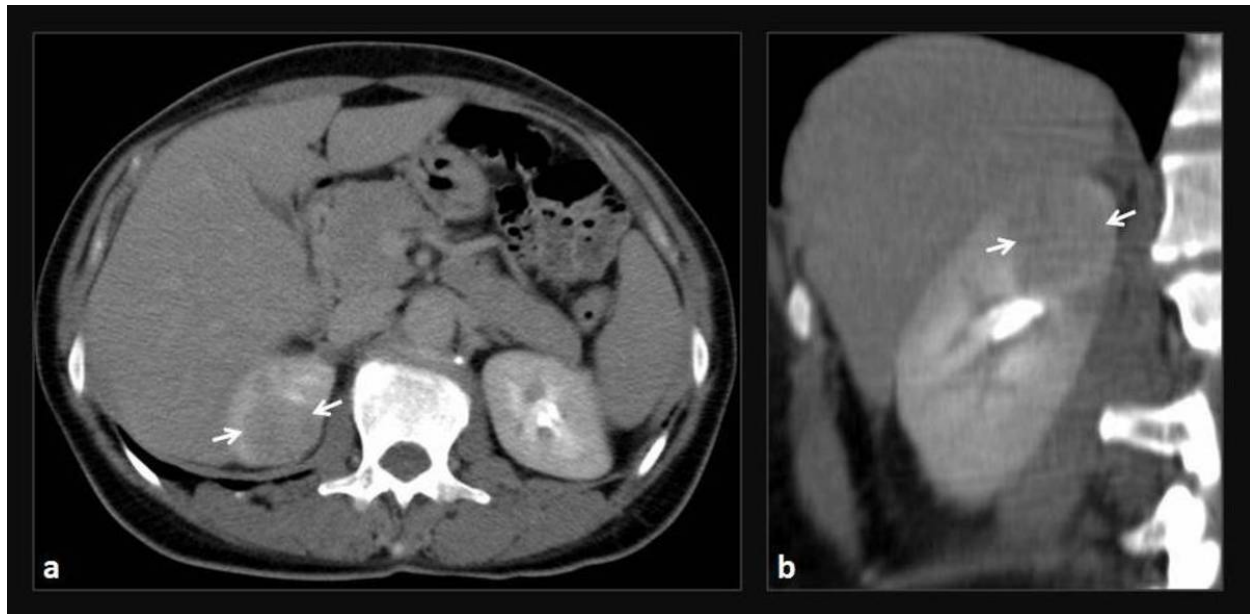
Focal acute pyelonephritis. Axial (a) and coronal (b) contrast-enhanced CT images (excretory phase) show a nodular hypodense area in the upper pole of the right kidney, representing a focus of pyelonephritis.
